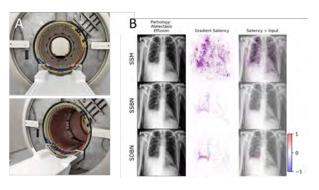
A: PET/MR system installed at UMC Utrecht. Top: Frontal view of the open bore. Bottom: Tilted view into the bore where the PET detector ring is installed. B: Saliency maps can help in guiding specialists to the correct diagnosis. Loss gradients were plotted with respect to their input pixels for the X-ray dataset. Rows top to bottom: Standard model (SSM), adversarially trained model with a single batch norm (SSBN) and dual batch norm (SDBN), [14].
